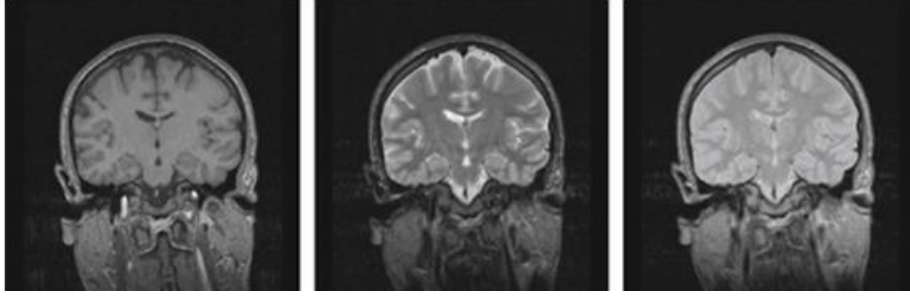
Brain MRI presetting (a)  $T_1$ , (b)  $T_2$ , and (c) hydrogen density weighted images.
